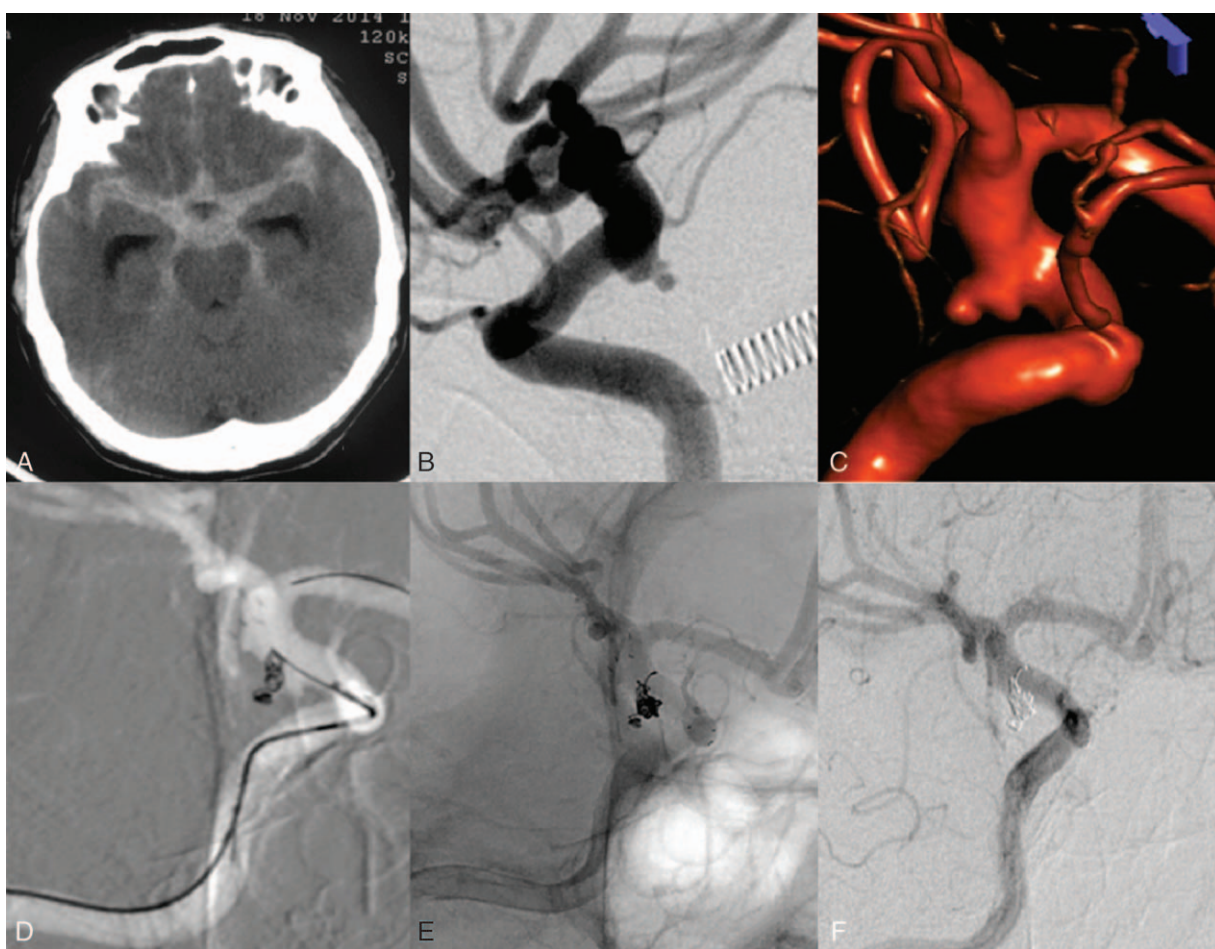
Images before and after Enterprise stent-assisted coiling embolization in a 65-year-old male that presented with a sudden headache and was hospitalized due to the onset of spontaneous subarachnoid hemorrhage. (A) Cranial CT on admission indicated: subarachnoid hemorrhage. (B and C) DSA images show a very small aneurysm in the right posterior communicating artery with a vesicle on the top. (D) The procedure of the enterprise stent assisted-coil embolization with the stent semi-released technique. An Enterprise-stent (4.5 × 22 mm) was placed in the parent artery past the aneurysm neck, and the coils (1 Complex coil and 3 hypersoft coils) were under the stent in the parent artery. (E) Postoperative immediate DSA images show that the degree of the occlusion was Raymond grade I. (F) 3 months after the intervention, the DSA follow-up indicated dense coil packing in the aneurysm (Raymond grade I), and the parent was patent without any stenosis. CT = computed tomography, DSA = digital subtraction angiography.
